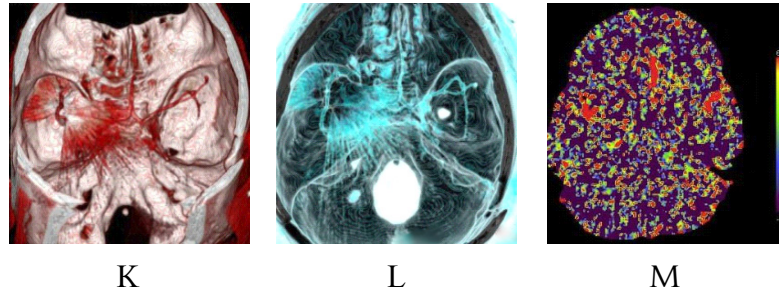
A-B cerebral CT scan showing missile in right temporal area; C cerebral CT scan with missile in parieto-occipital area; D CT scan shows the skull fracture underlying cerebral contusion and an intrusive parietal bone fragment, E-G axial cerebral CT scan showing haemorrhagic missile tracks with adjacent small cerebral contusions; H-I temporo-parietal peritentorial bullet on axial and coronal reconstruction cerebral CT scan K-L angio-CT scan 3D shows metallic bullets in both hemispheres, no pseudoaneurysm or dural sinus tear, M SPECT with severe cerebral ischemia
